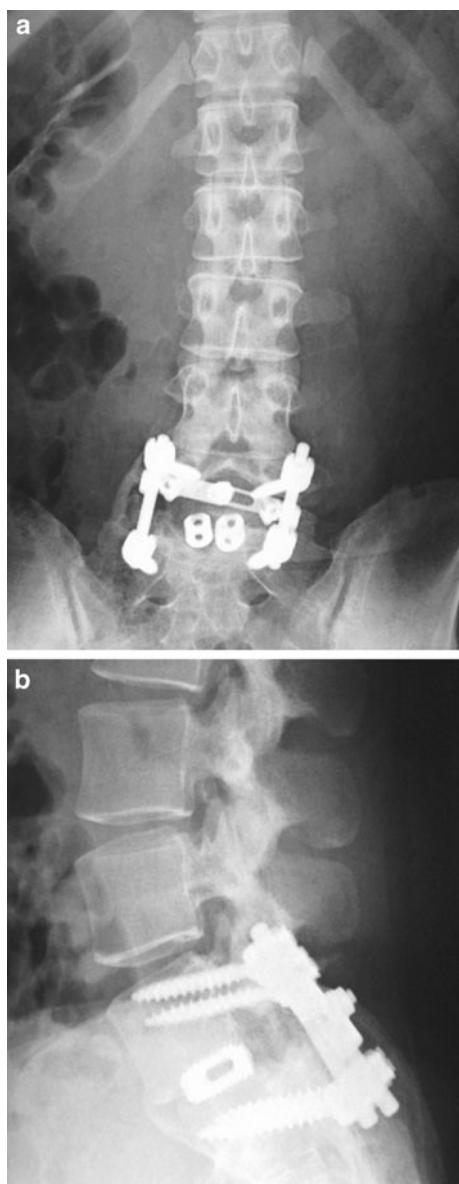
Anteroposterior (a) and lateral (b) postoperative radiographs showing corrected anatomic alignment
